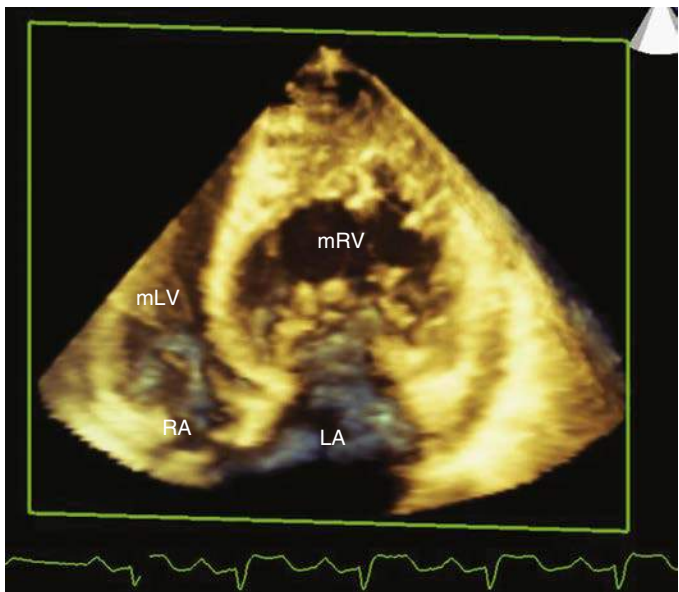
Three-dimensional transthoracic echocardiography image in a case of congenitally corrected transposition of the great arteries (cc-TGA) showing the morphology of a hypertrophied right ventricle located on the left, thickened tricuspid valve (TV), with a severely dilated left atrium. LA, Left atrium; mLV, morphologic left ventricle; mRV, morphologic right ventricle; RA, right atrium.
